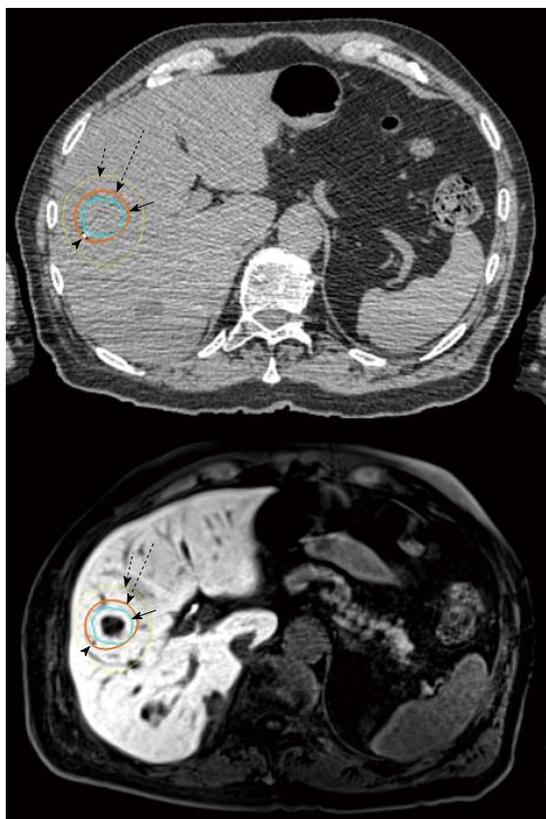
Demonstrating the tight prescription isodose (long broken arrow) around the planning target volume (solid arrow). The steep dose fall gradient is demonstrated by the 50% isodose curve (short broken arrow) around the prescription isodose. Platinum fiducials showed as arrow head as seen in both computed tomography and magnetic resonance imaging.
